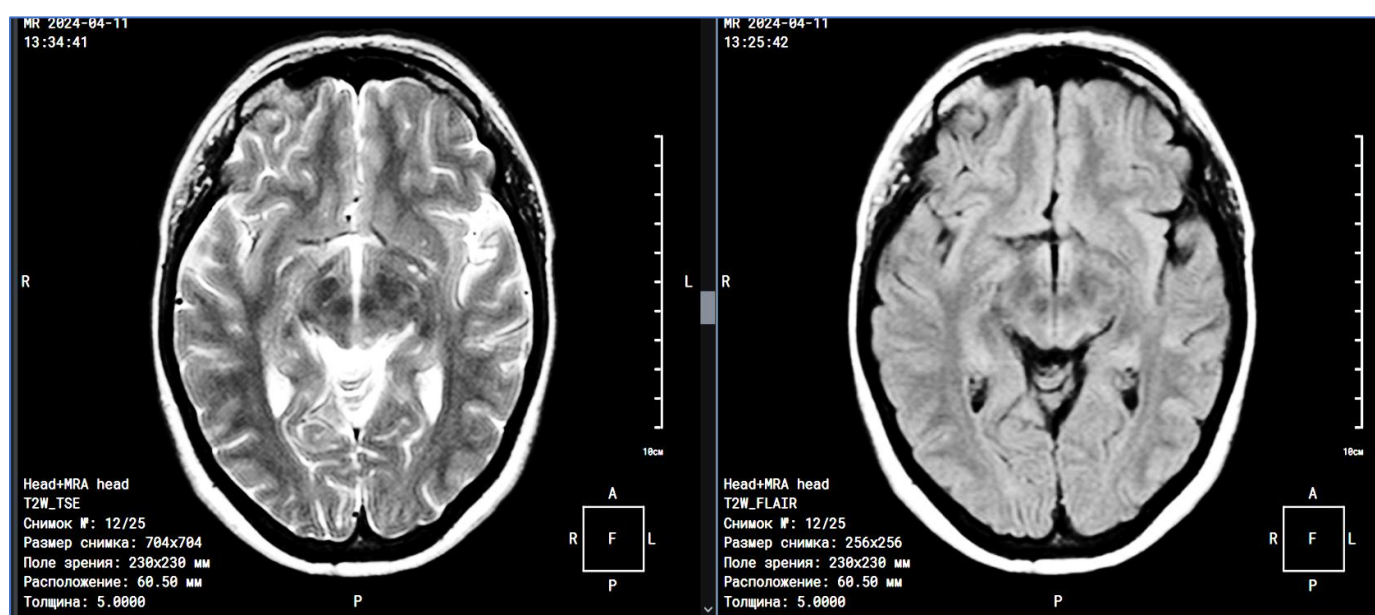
Brain MRI of the patient Sh.E.E. (42 years old): "giant panda face" phenomenon in the midbrain.
